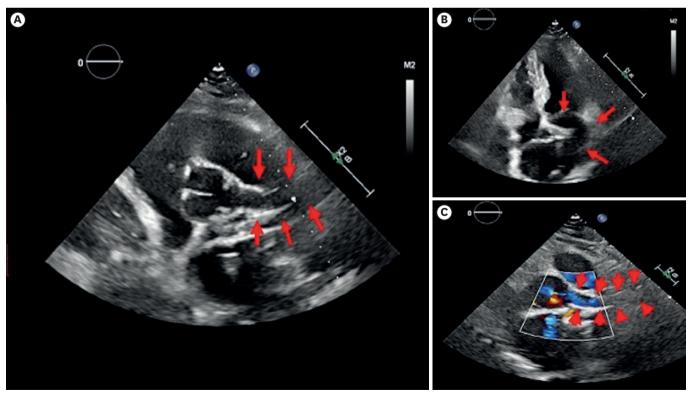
The transthoracic echocardiogram parasternal short axis (A) and apical 4-chamber view (B) showed an anomalous structure (red arrows) connecting from the aortic cusp. Color Doppler short-axis view (C) showed flow from the aortic cusp into an abnormal tract while the normal left coronary artery is not seen, indicating an anomalous origin of the left coronary artery.
